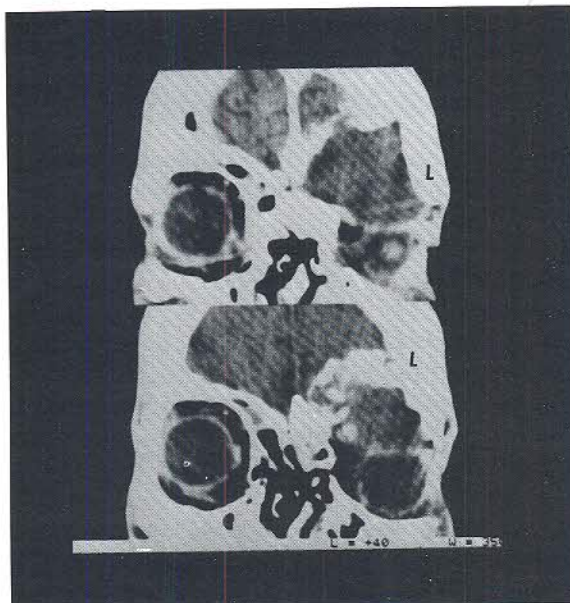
Case 3. CT scan (without contrast) taken preoperatively shows a mucocoele involving the left frontal and ethmoid sinuses and extending into the orbit and anterior cranial fossa.
